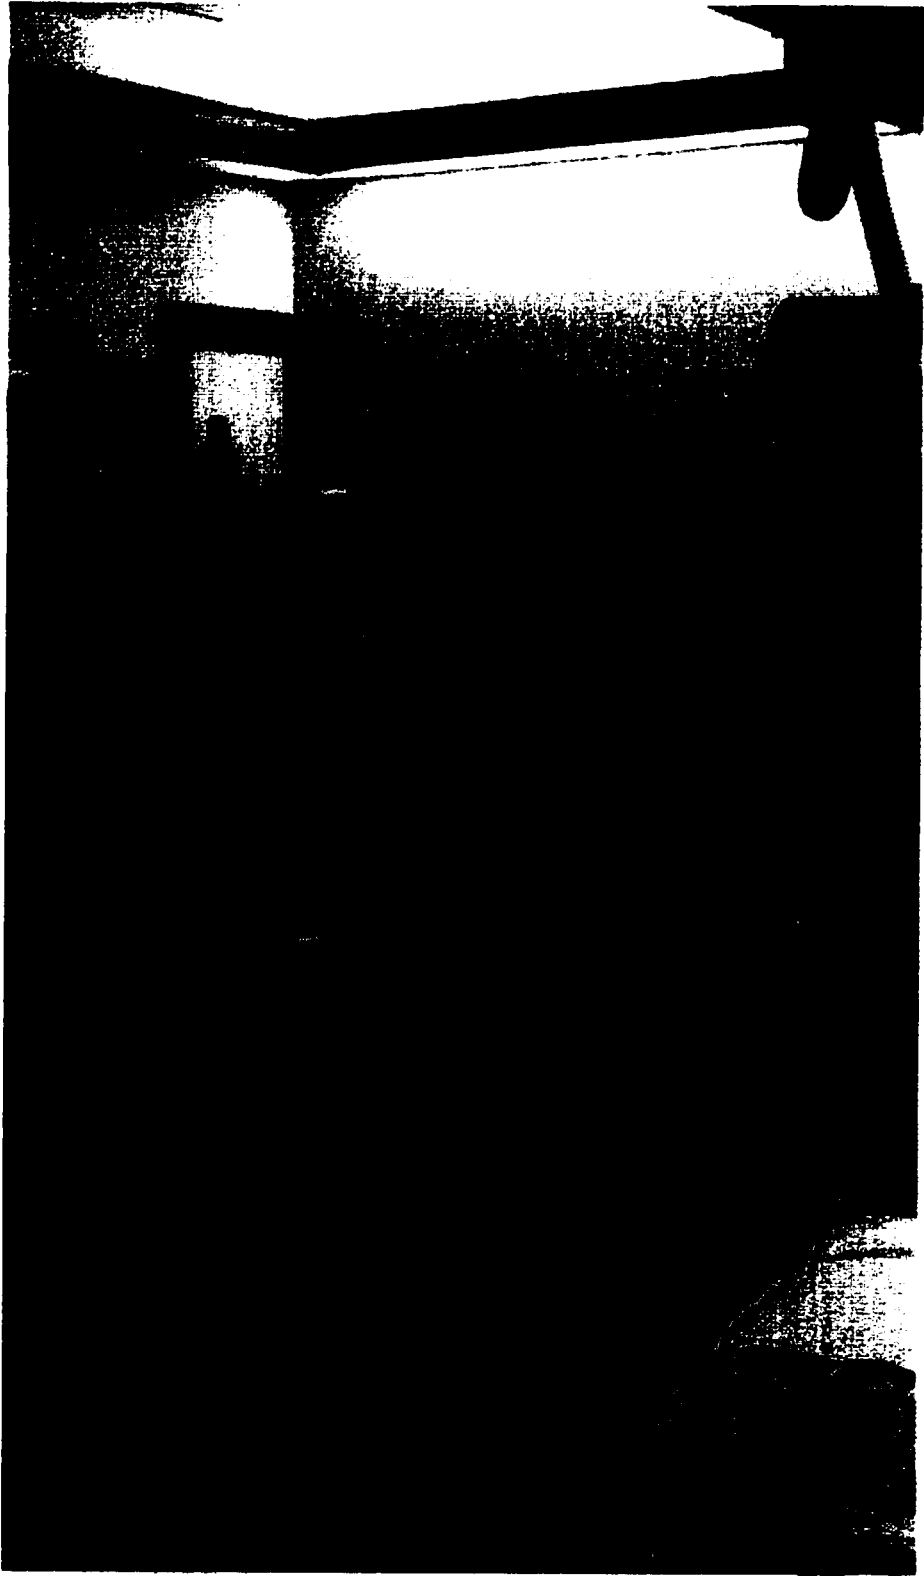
Experimental setup used in FOB X-RAY experiments.
